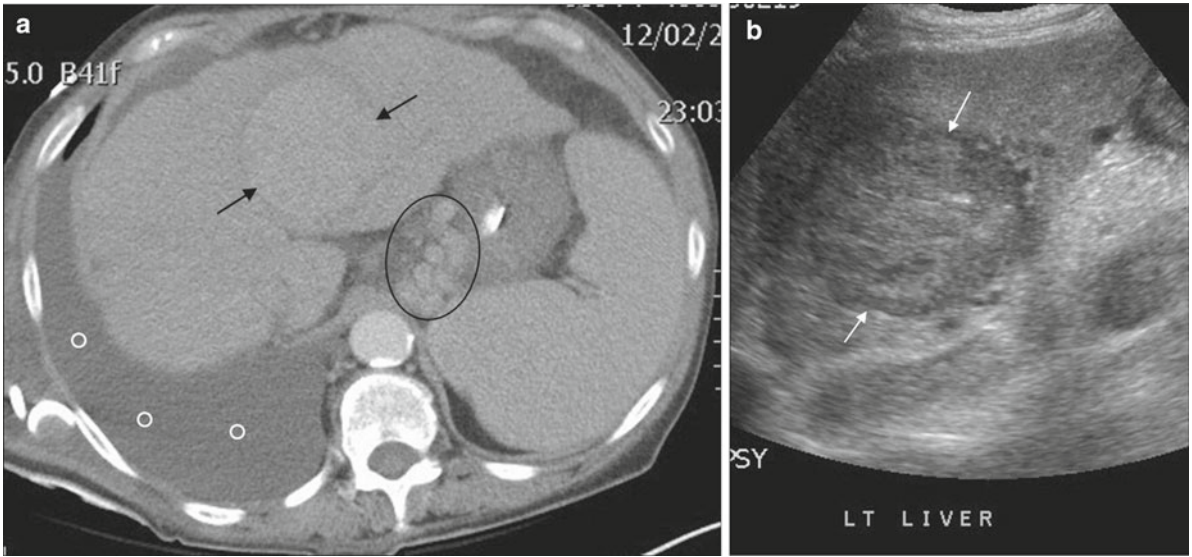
A 69-year-old man with hepatic encephalopathy. (a) Axial intravenous contrast enhanced CT image through the upper abdomen shows a mass in the liver (*black arrows*). The liver is small and irregular-cirrhotic. There is splenomegaly; small amount of ascites and large
